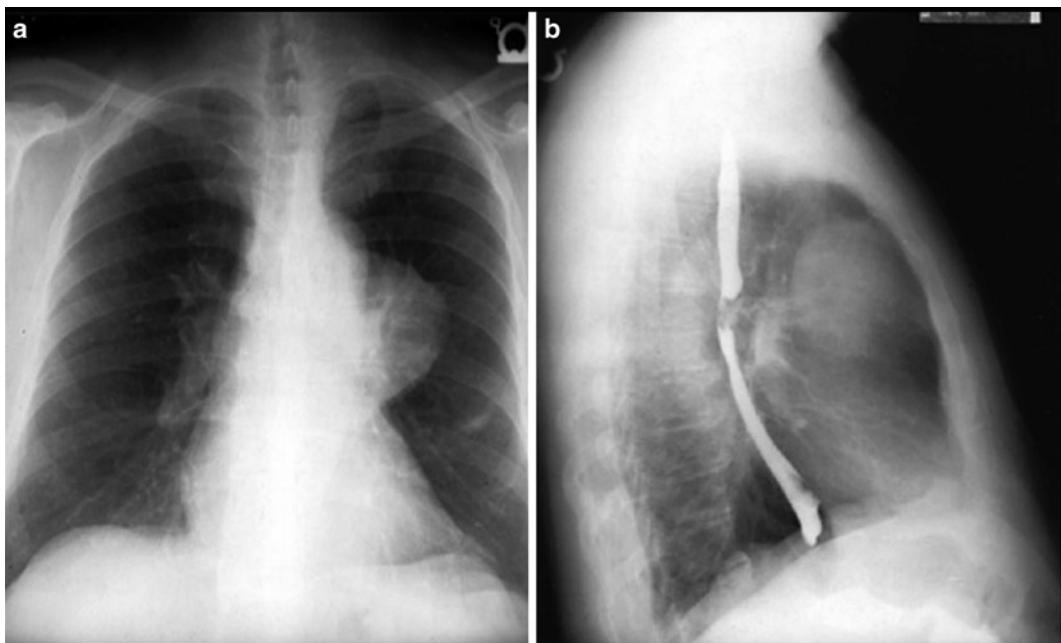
(a) An anterior mediastinal mass in the left hemithorax of the posteroanterior chest radiograph. (b) A lateral radiograph with esophageal contrast where there is a mediastinal mass without compromise to the tracheobronchial tree.
